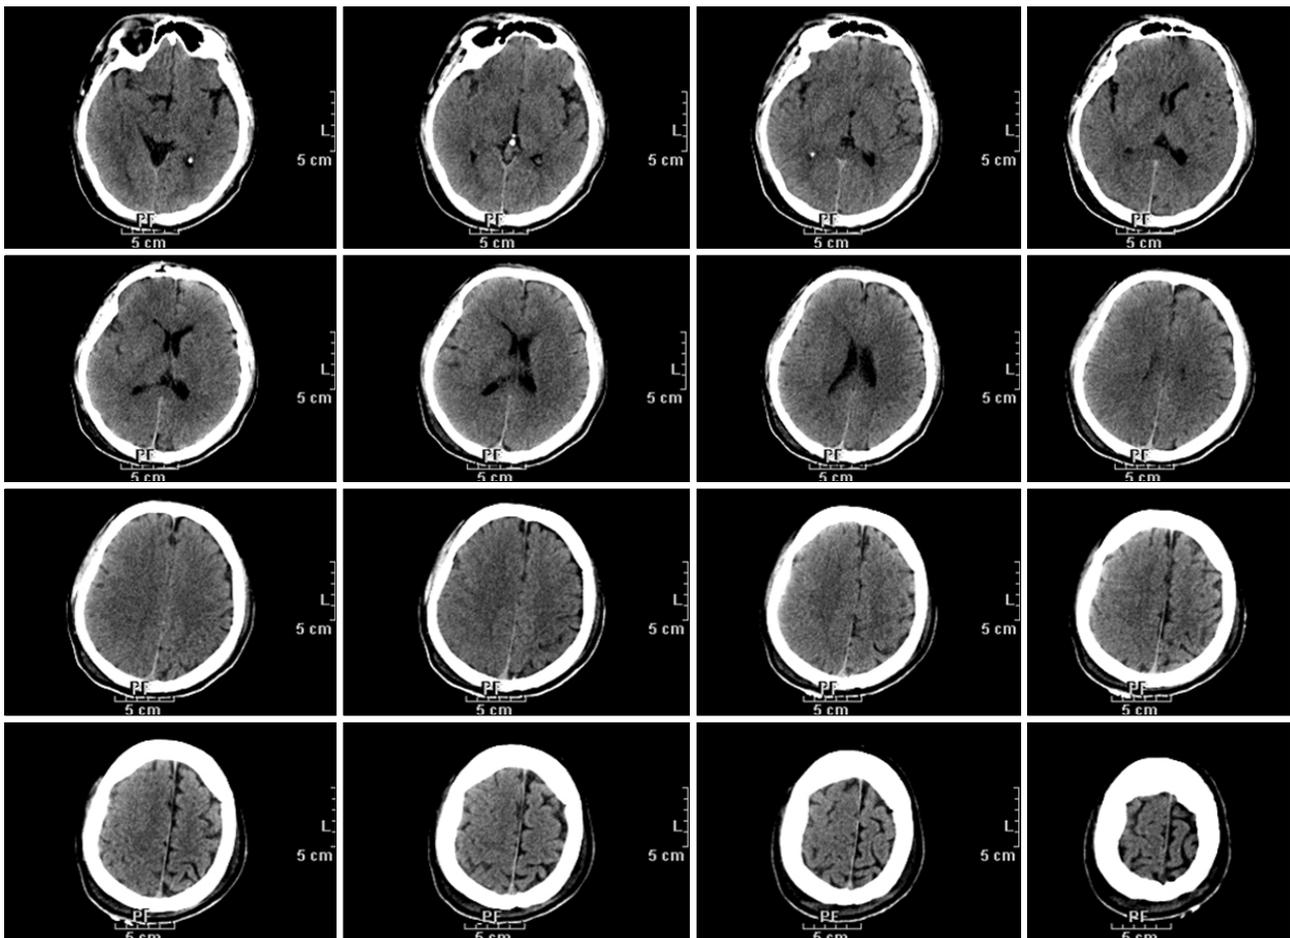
Brain CT scan showed the swelling of right hemisphere with effacement sulcal space and suspected ischemic damage.
